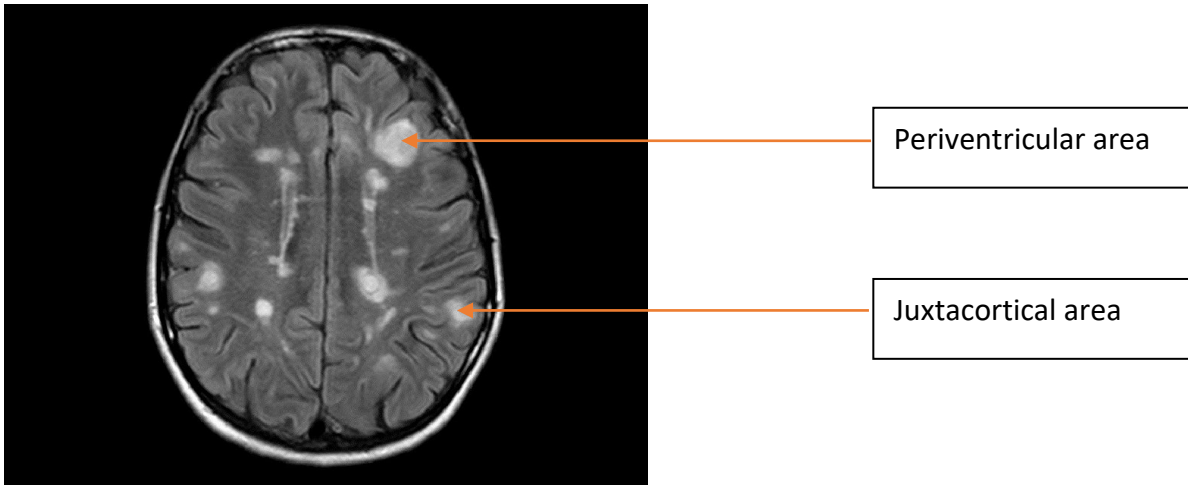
Magnetic resonance image of myelin lesions in periventricular and juxtacortical areas. The periventricular area is oriented into the lumen of the third ventricle, whereas the juxtacortical area is in the proximity to the cortex. The image was adopted from Essilfie et al., (2020).
